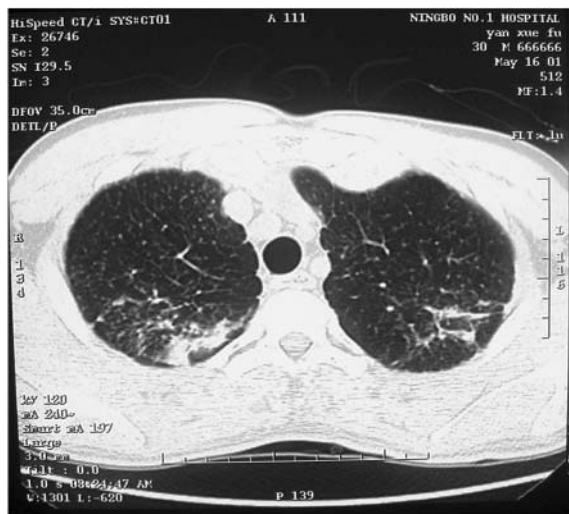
The same case, HRCT revealed 10 mm x 15 mm large opacities in right upper lung field.
